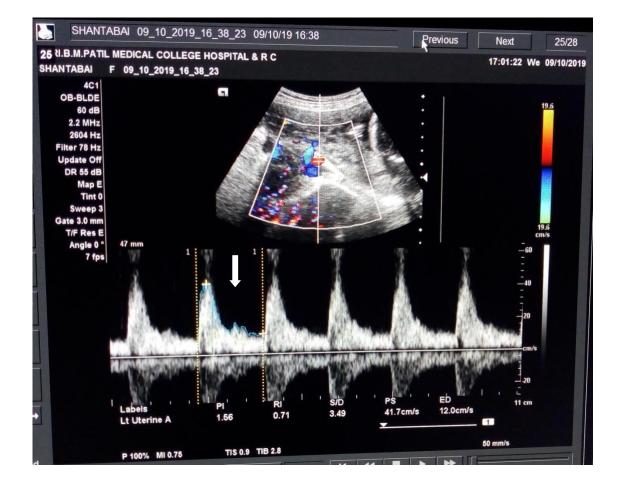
Uterine Artery Doppler with Increased S/D ratio – 3.49, increased PI – 1.56 and Increased RI – 0.71
